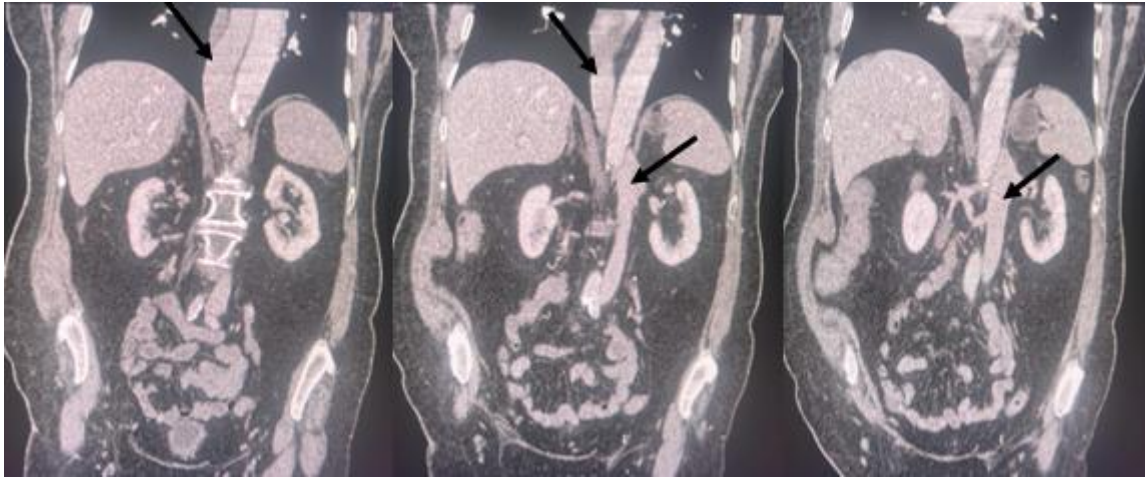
Contrast-enhanced abdominal-pelvic CT scan in axial plane with coronal reconstructions: inferior vena cava duplication.
